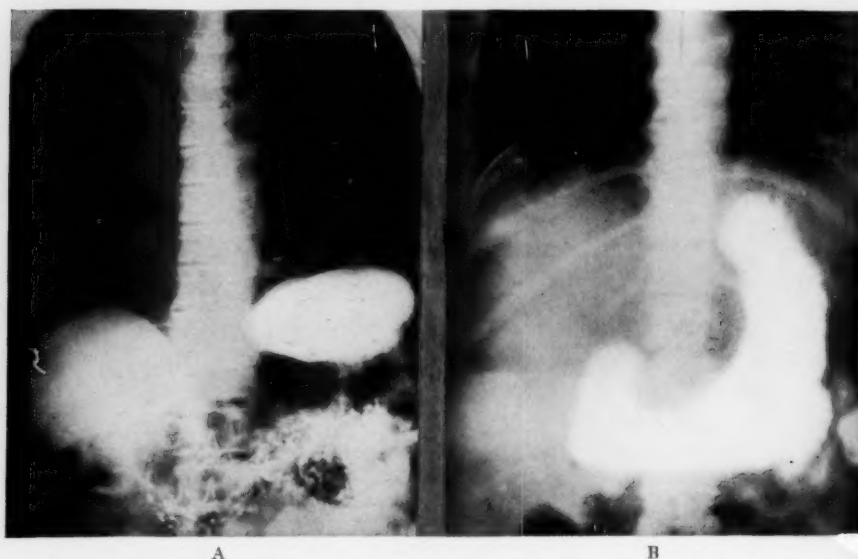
Roentgenograms showing (A) the normal relationship of the barium filled stomach to the diaphragm; and (B) the downward and medial displacement of the stomach by the subphrenic abscess in Case 4.
